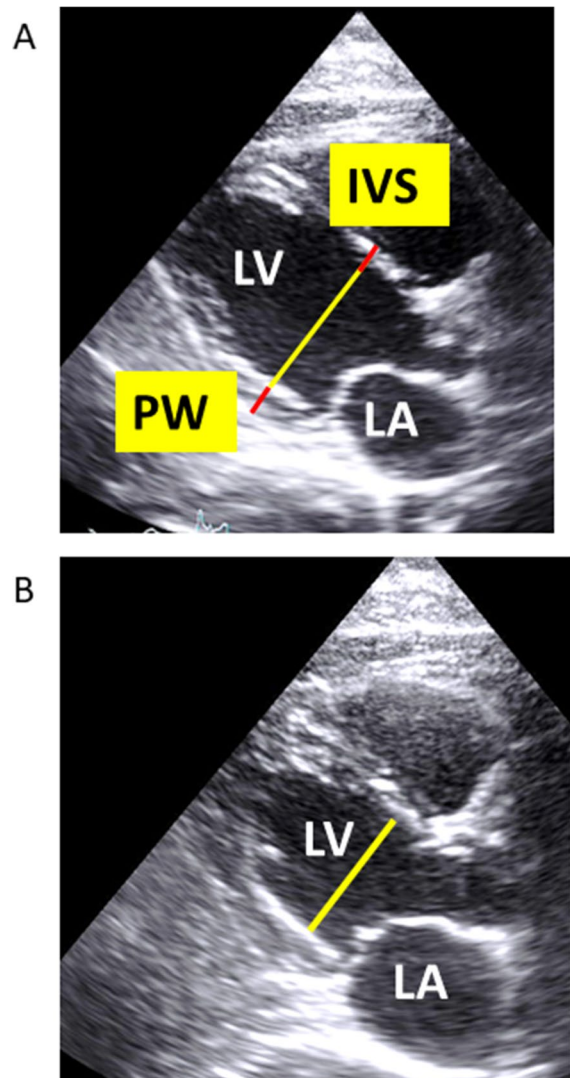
Representative 2D TTE images of the parasternal long axis view of the heart. A Diastolic and B Systolic frames. Examples of measurements of the diastolic and systolic diameters of the left ventricle (LV) and of the interventricular septal (IVS) and posterior wall (PW) thickness. (LA: left atrium)
